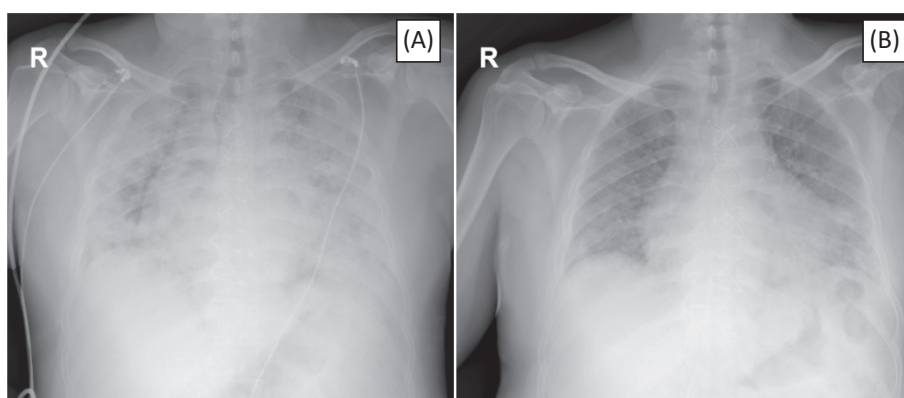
Comparison of the patient's x-rays from the apex to basal at the time of ICU admission (A) and at the time of discharge (B).
